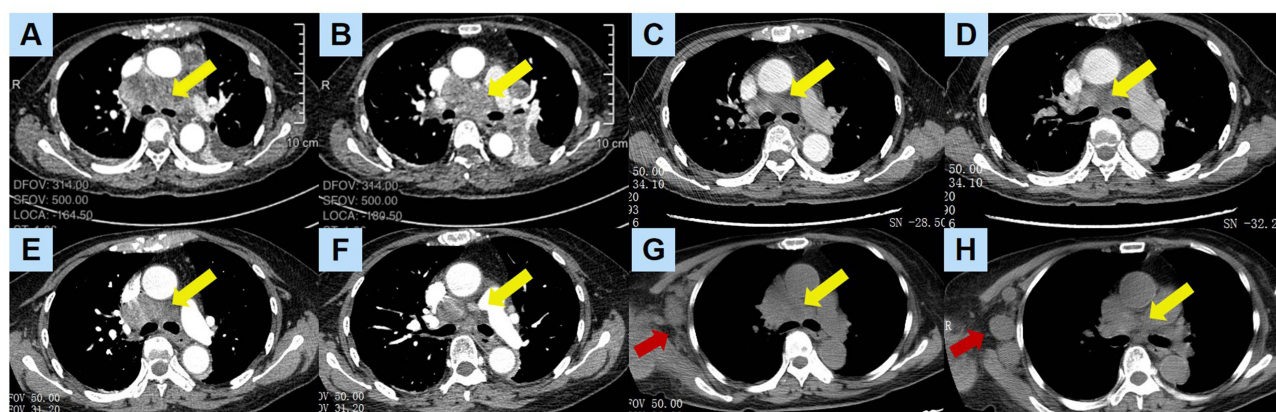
Chest CT scans at different time points. (A and B) baseline (3/2023), multiple enlarged mediastinal lymph nodes, with the largest measuring of 44.2*30.8mm; (C and D) after Afatinib treatment (5/2023), multiple enlarged mediastinal lymph nodes, with the largest measuring of 19.8*16.0mm; (E and F) the first time with disease progression (11/2023), multiple enlarged mediastinal lymph nodes, with the largest measuring of 37.4*25.7mm; (G and H) the second time with disease progression (2/2024), fusion of enlarged lymph nodes with maximum diameter of 48.0*27.2mm; a right axillary lymph node with maximum diameter of 25.5*19.4mm; Yellow arrows denote mediastinal lymph node lesions; red arrows indicate the axillary lymph node lesion.
